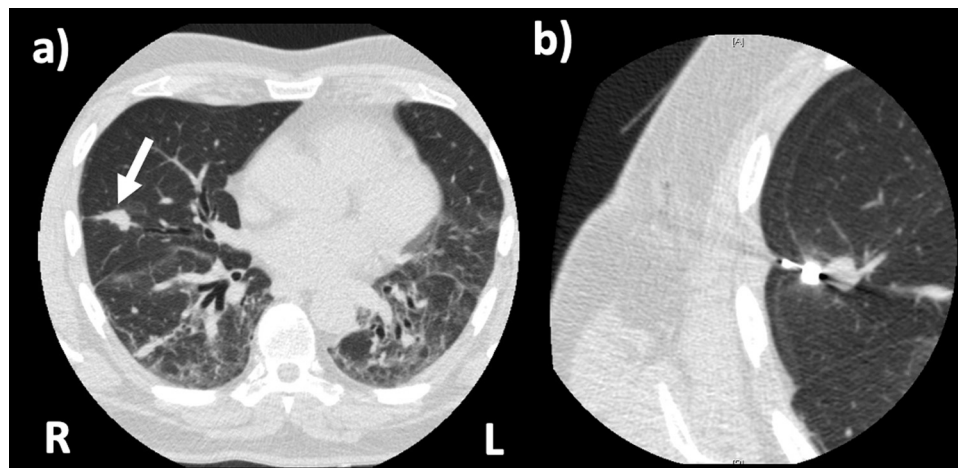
CT guided microwave ablation performed on December 5, 2018. (A) Right middle lobe lesion. (B) Right middle lobe lesion targeted with 75 watts for 7 minutes to achieve a 3 cm destruction zone.
